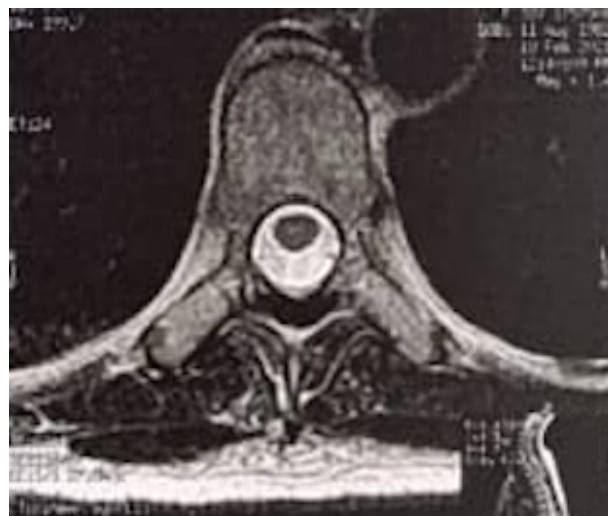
Postoperative Magnetic Resonance Imaging: a laminectomy was performed on T4 and T5 to collect extradural fluid on the laminectomy level corresponding to the seroma. There was a slight degenerative change in the thoracic backbone and slight edema in the paravertebral muscular at the surgical site.
